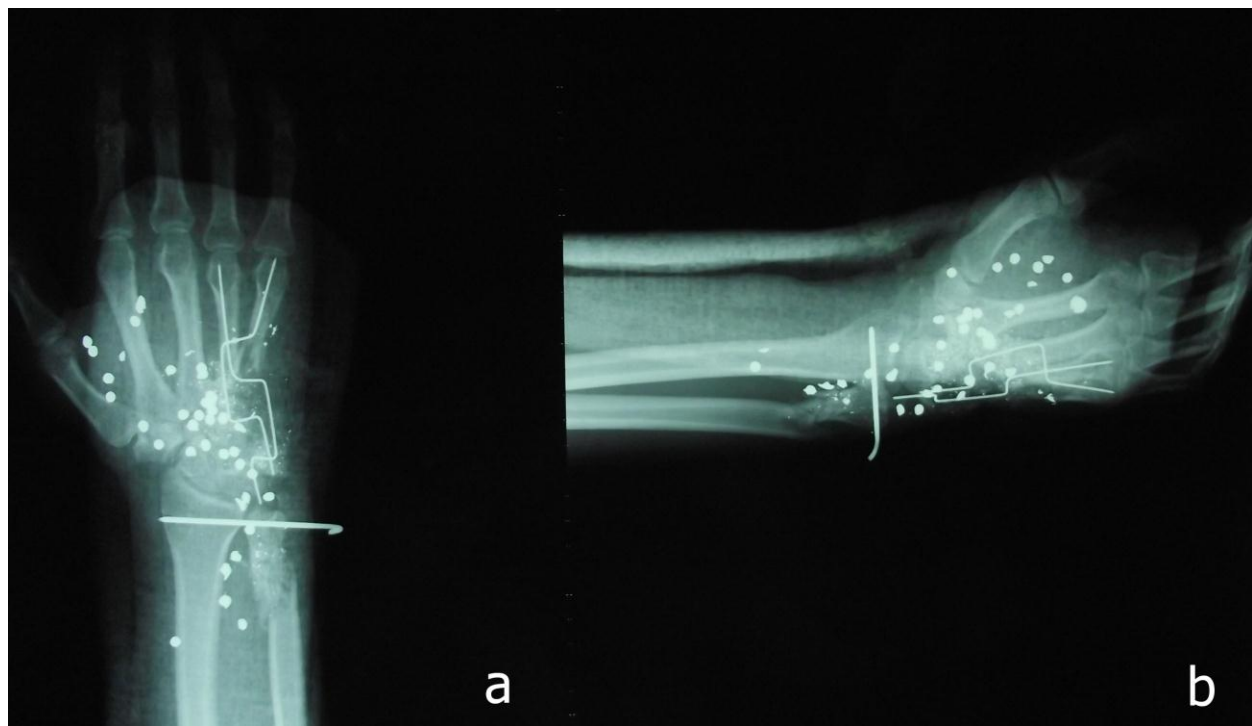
a)-b) Postoperative anteroposterior and lateral radiograph of hand after plate was applied for metacarpal fractures in second surgery.
